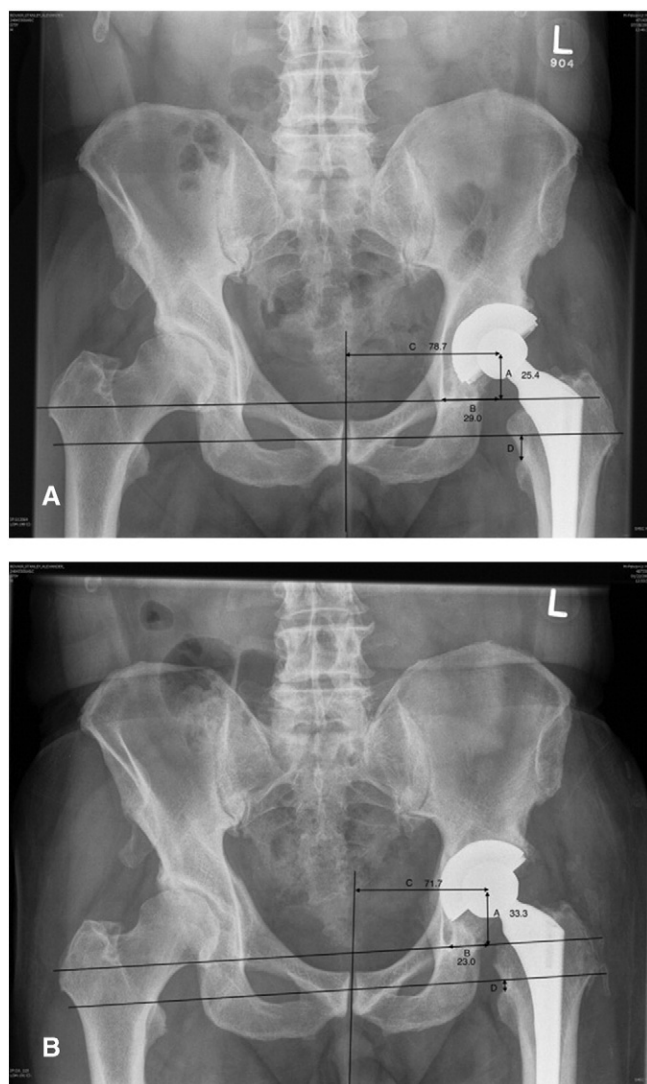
(A) Pre-operative AP radiograph of the pelvis. (A) Height of the hip center; (B) Horizontal location of the center of the hip; (C) Center body moment arm; (D) Leg length discrepancy. (B) Post-operative AP radiograph of the same patient, with identical measurements as in (A). The centre of rotation of the hip has been both medialized (demonstrated by a decrease in (B) and (C) measurements) and placed more superiorly (demonstrated by a reduction in (A)). The leg length discrepancy (D) has also been reduced.
